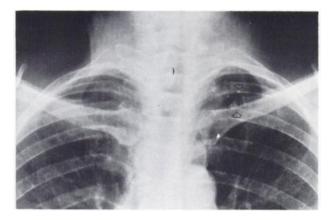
Chest x-ray showing iodine in lymph node.
